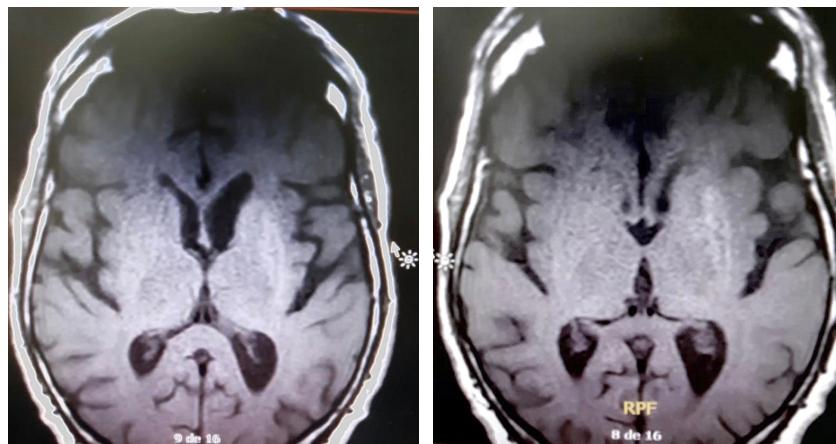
T1-weighted axial plane Nuclear Magnetic Resonance image showing a slight increase in signal intensity in the basal nucleus, especially in the head of the caudate nucleus and the lenticular nucleus, with less involvement in the internal capsule on the left side compared to the first images.
